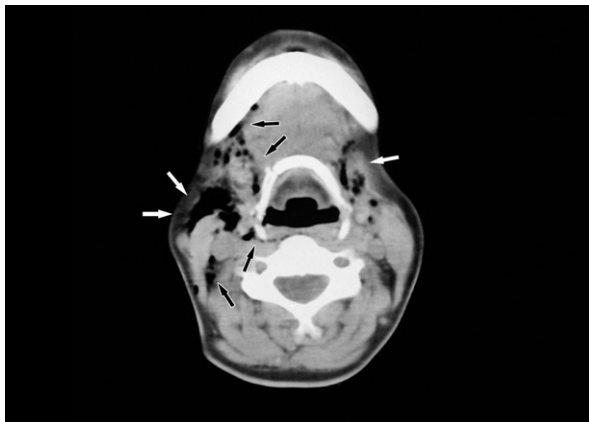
CT scan at the level of the hyoid bone. Air (arrows) can be observed in the right submandibular space, carotid space, retropharyngeal space, and cervical subcutaneous tissue on the opposite side.
